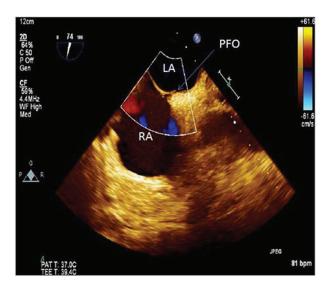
Transoesophageal echocardiogram showing small patent foramen ovale.
